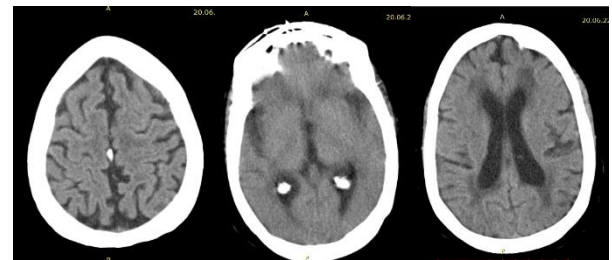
69-year-old woman with COVID-19 who presented with sudden right-sided weakness CT Scan image showed a sub-acute left basal ganglia infarct with periventricular and deep white matter hypodensities and prominence of the sulci and gyri with dilated ventricles.
